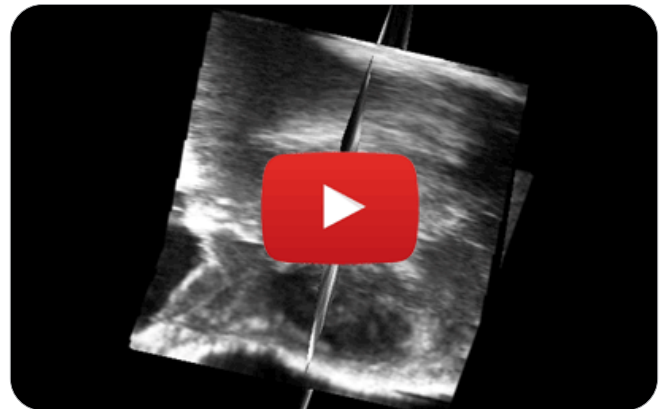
3D ultrasound in live motion.
